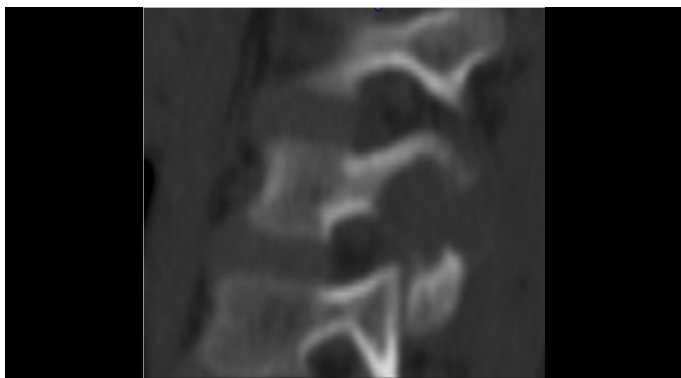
Lumbar CT scan in a patient with L3 facet involvement. Instability in the sagittal plane due to facet involvement is observed.
